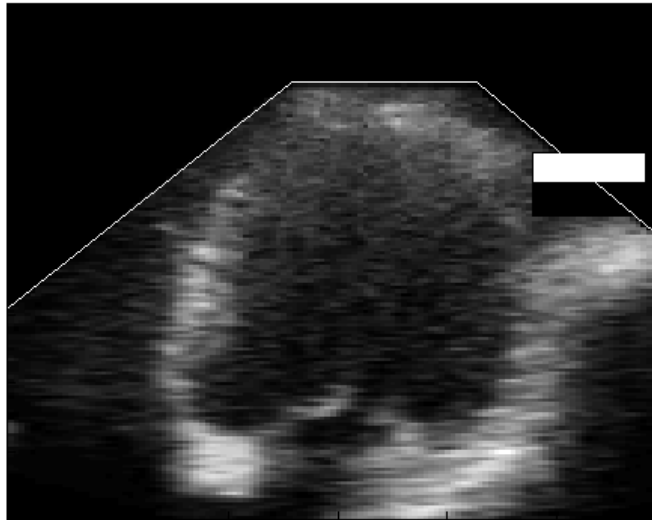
the image boundaries problem. The black-white rectangle is our Haar feature. The region within the ultrasound sector (under the white line) is valid and the one outside of it invalid.
